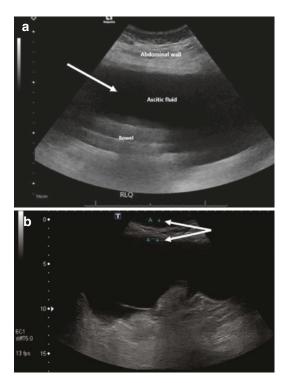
(a) Ultrasound image showing abdominal wall and bowel with arrow pointing to ascitic fluid. (b) Arrows showing measurement of the abdominal wall thickness
